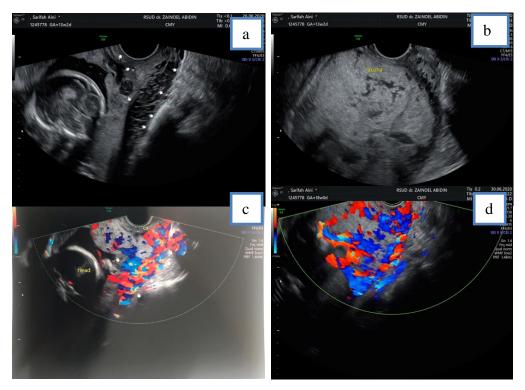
Placenta accreta ultrasonography (USG): Shows a bridging vessel image on the placenta (a,c), shows a lacuna on the placenta (b,d) (sources: Department of Obstetrics and Gynaecology, Zainoel Abidin Hospital, Banda Aceh Indonesia)
